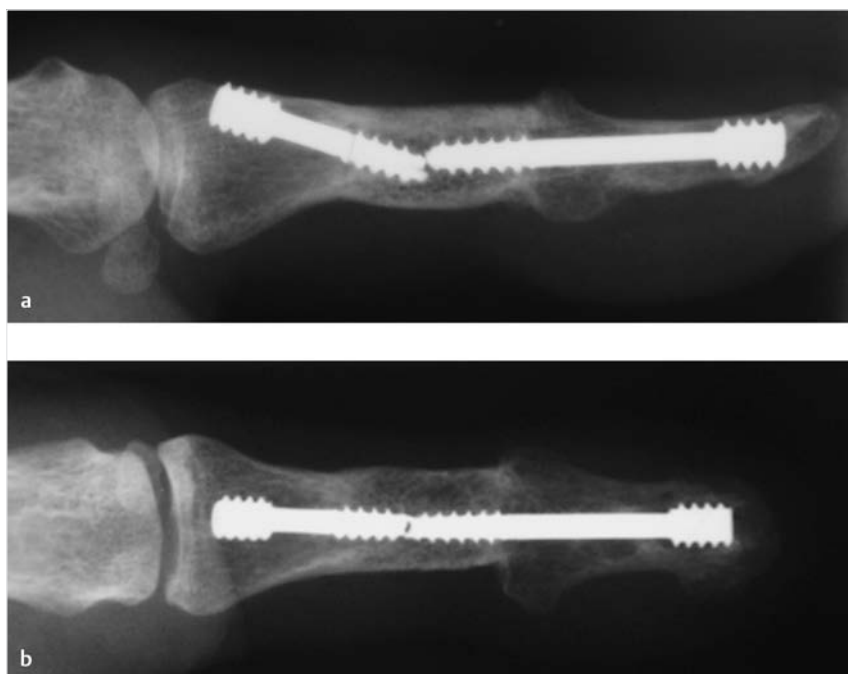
(a, b) Radiograph showing bony union between the graft and the phalanx.
